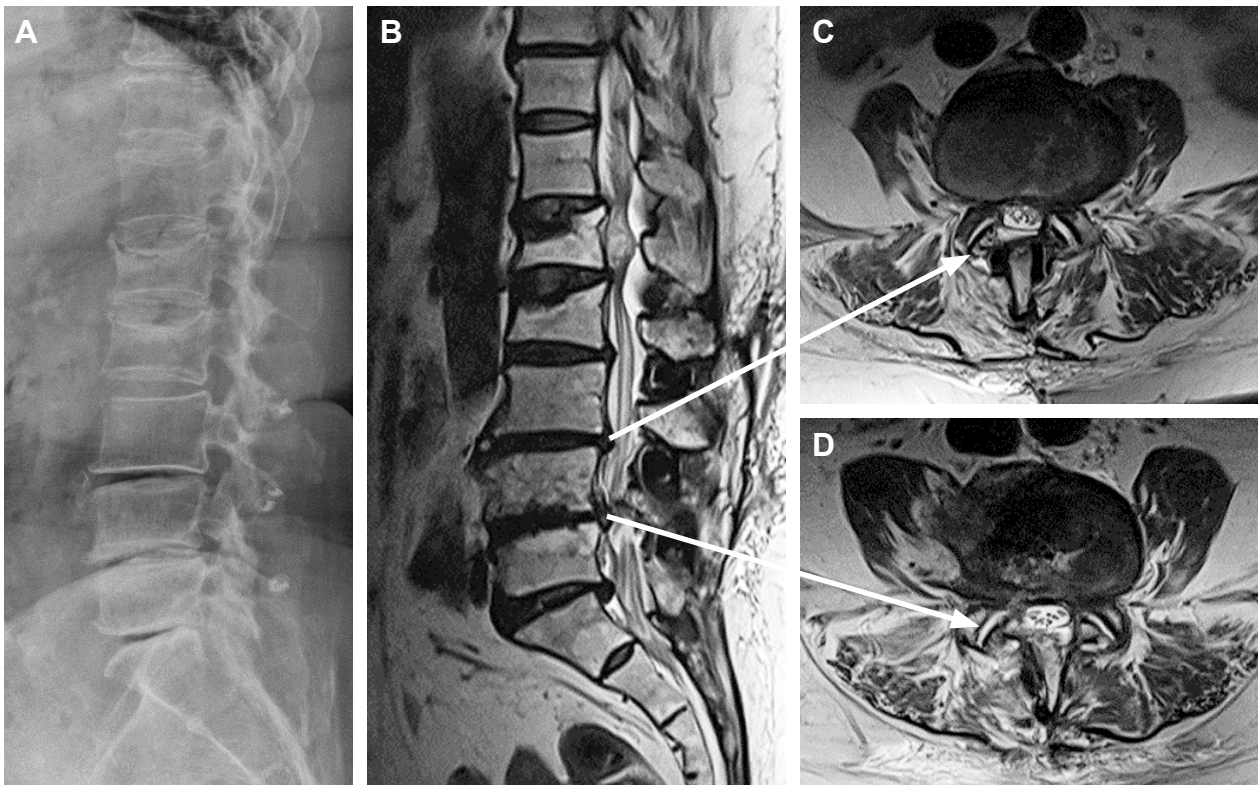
A case with persistent back pain and lower leg numbness caused by multiple DIAMs. (A) X-ray and (B) MRI images in the sagittal plane. (C and D) MRI images in the axial plane. DIAM: Device for Intervertebral Assisted Motion; MRI: Magnetic resonance imaging.
